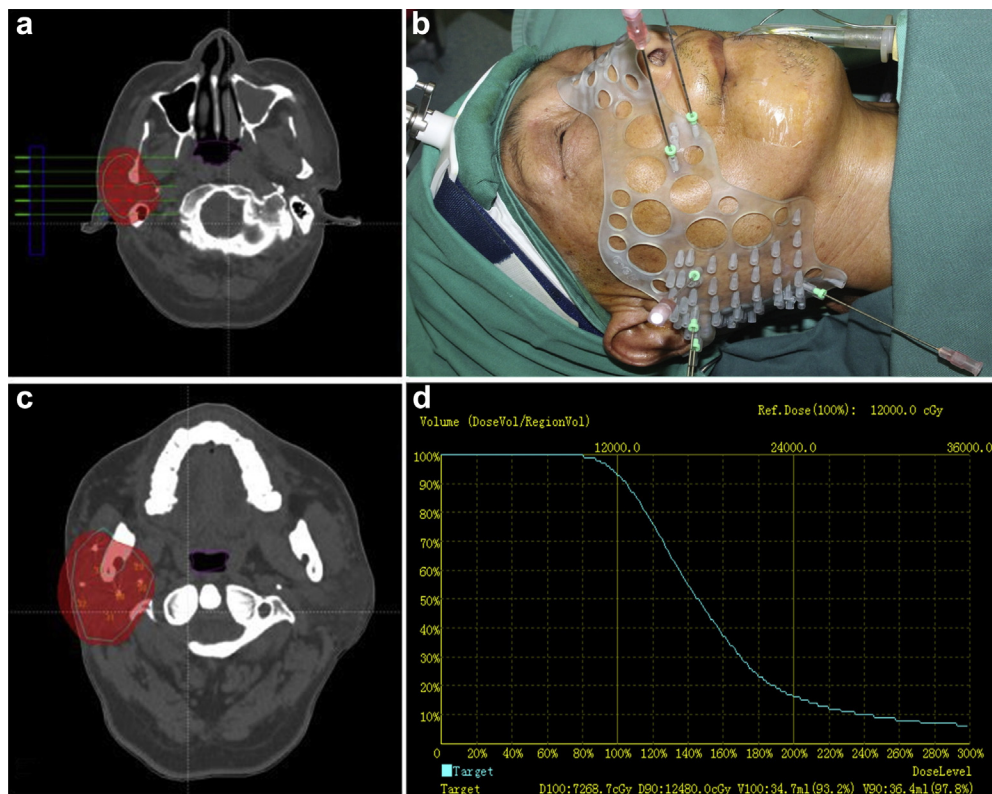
The administration of iodine-125 seeds parotid brachytherapy. (a) The isodose curve in the implant plan from CT scan. (b) Hollow interstitial needles were inserted into the target region, and I-125 radioactive seeds were implanted permanently according to the preplan with customized template guidance. (c) The isodose curve after seed implantation from CT scan. (d) The dose-volume histograms of the planning target volume after seed implantation.
